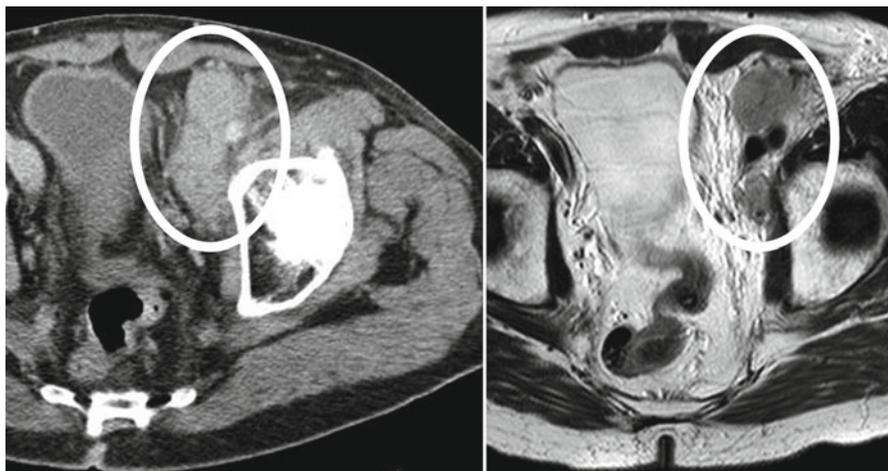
Axial CT and T2 MRI image at the same level demonstrating equal conspicuity of left pelvic nodal disease from bladder cancer. MRI is better at T-staging than CT, but both have similar accuracies in nodal detection
